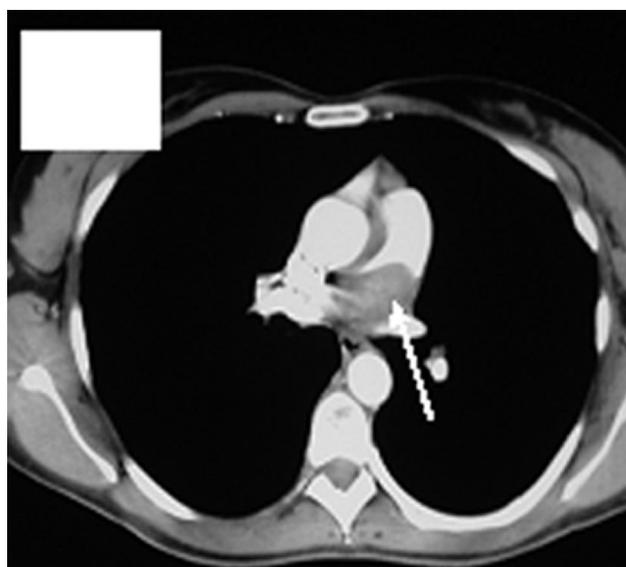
Contrast-enhanced CT of the pulmonary arteries. Cross section through the chest at the level of the infundibulum. A poorly enhanced filling defect is demonstrated in the main pulmonary artery (arrow).
